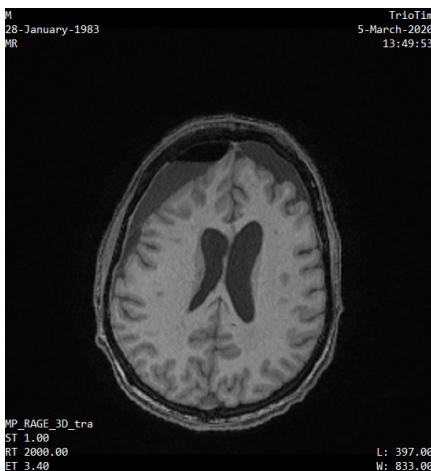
Patient's K. MRI scan.
